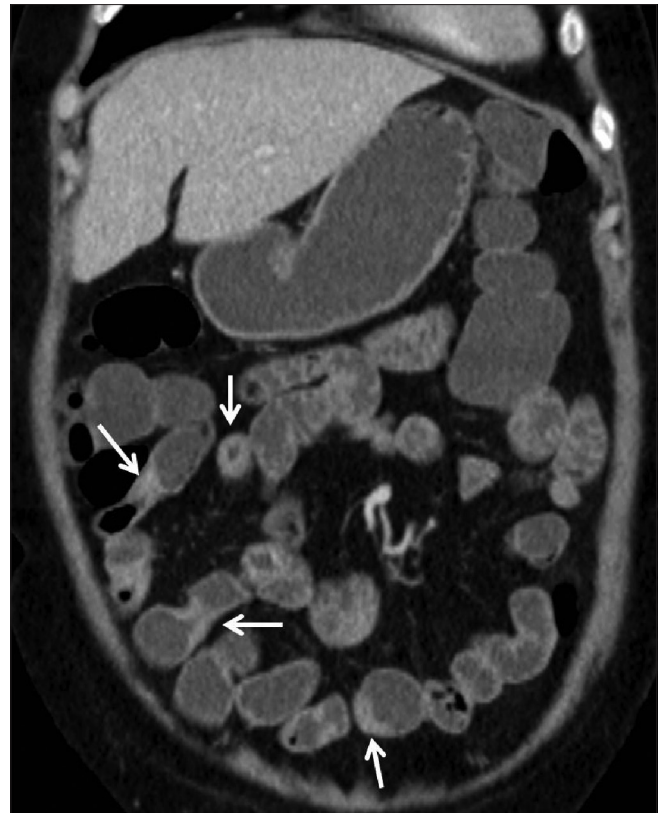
Computed tomography enterography image showing multiple short segment strictures (arrows) in proximal and midileal loops with mild proximal dilatation. The findings are nonspecific and may be seen in both intestinal tuberculosis and Crohn's disease
